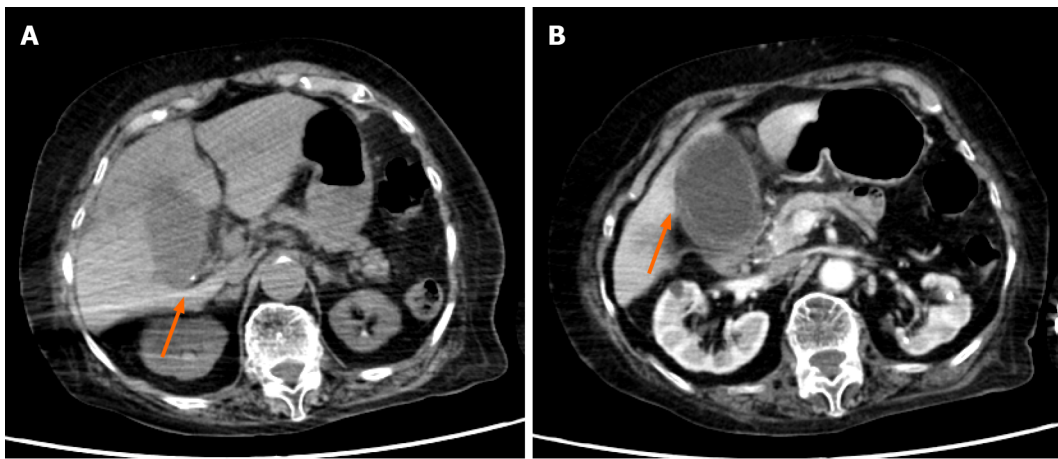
An abdominal contrast-enhanced computed tomography (Case 1). A: Small calculus in the gallbladder neck (arrow); B: Significant swelling of the gallbladder and asymmetrical wall thickening. The gallbladder wall indicated parts with either poor or no contrast enhancement (arrow), with a partial failure of continuity of the mucosa.
